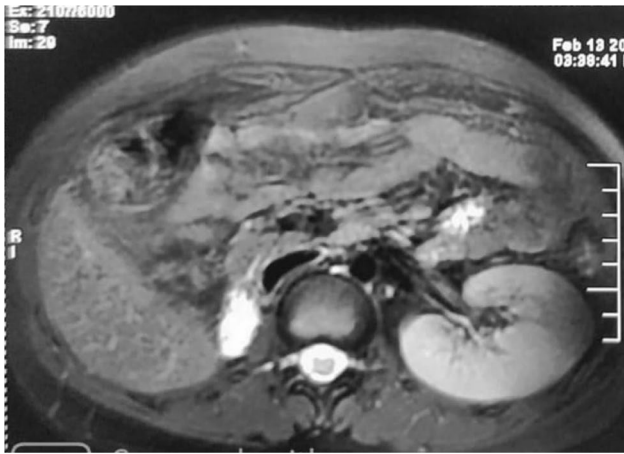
MRI abdomen showing absent right kidney. Normal left-side kidney was present
